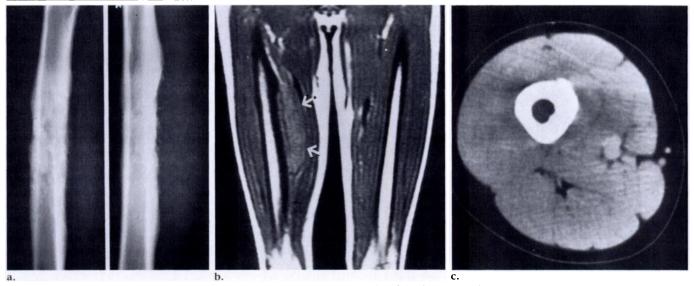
Parosteal Ewing sarcoma. (a) Lateral and anteroposterior radiographs of the femoral shaft reveal cortical thickening, which is associated with surface scalloping and irregular perpendicular spicules of periosteal new bone. (b) Coronal T1-weighted magnetic resonance (MR) image (spin echo [SE]; repetition time msec/echo time msec, 500/20) shows the lesion (arrows) to arise on the surface of the medial cortex. The underlying medullary cavity is normal. (c) Contrast material—enhanced CT image. The findings confirm the absence of medullary involvement. The soft-tissue mass, however, is much better appreciated on the MR image.
